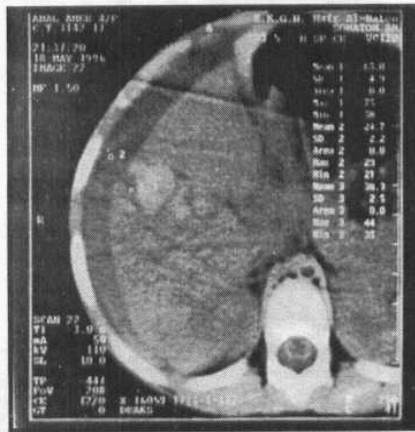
CT Scan showed a Rt. hepatic Fracture with intra parenchymal hematoma and haemoperitoneum.
